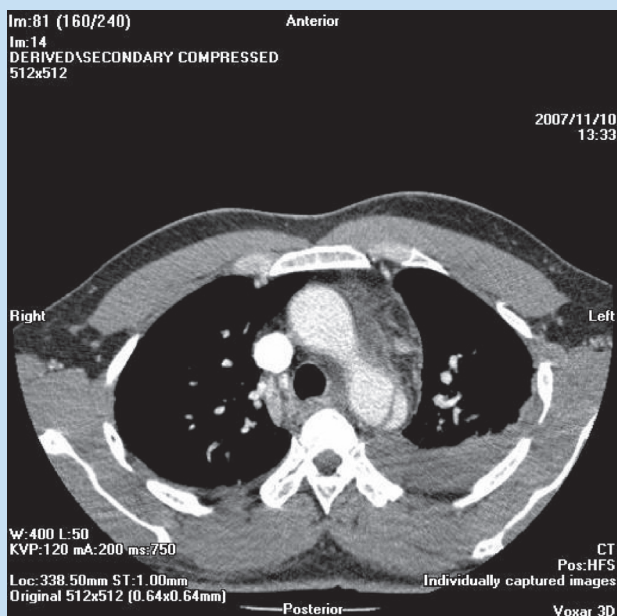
Post-contrast chest CT angiogram (axial view), demonstrating a tear in the distal aortic arch associated with a left haemothorax.
